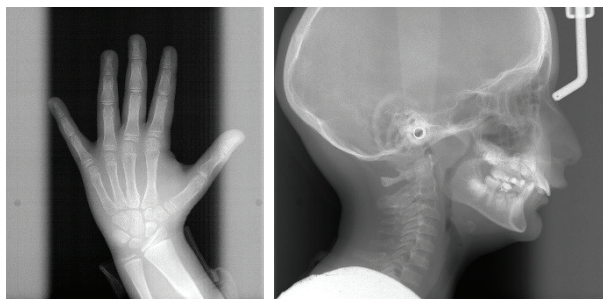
Initial radiographs
